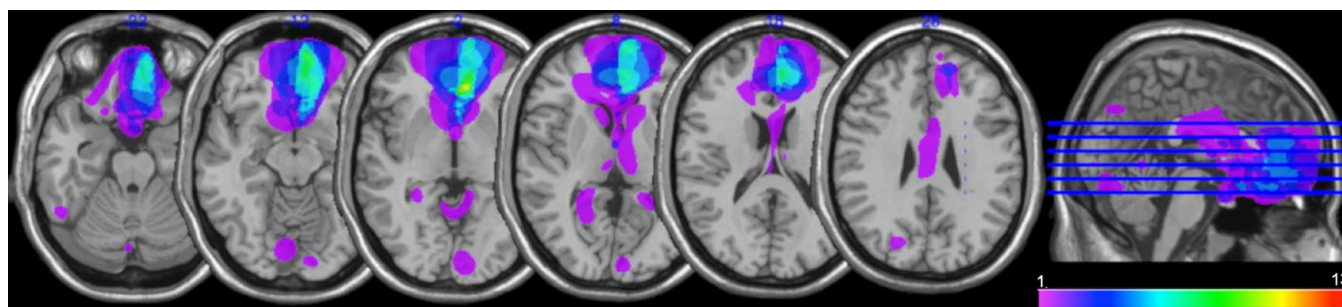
Lesion overlap in 13 individuals with ventromedial prefrontal cortex (vmPFC) damage superimposed on an averaged structural MRI scan. Slices are 8-mm apart ($z = -30, -22, -14, -6, +2$, and $+10$). The color bar indicates the number of individuals with damage to a particular area: Purple represents regions damaged in only one individual, and red represents regions damaged in all 13 individuals. The image was created using *MRICro* software (Rorden & Brett, 2000). See Table S1 for lesion locations in each vmPFC case.
